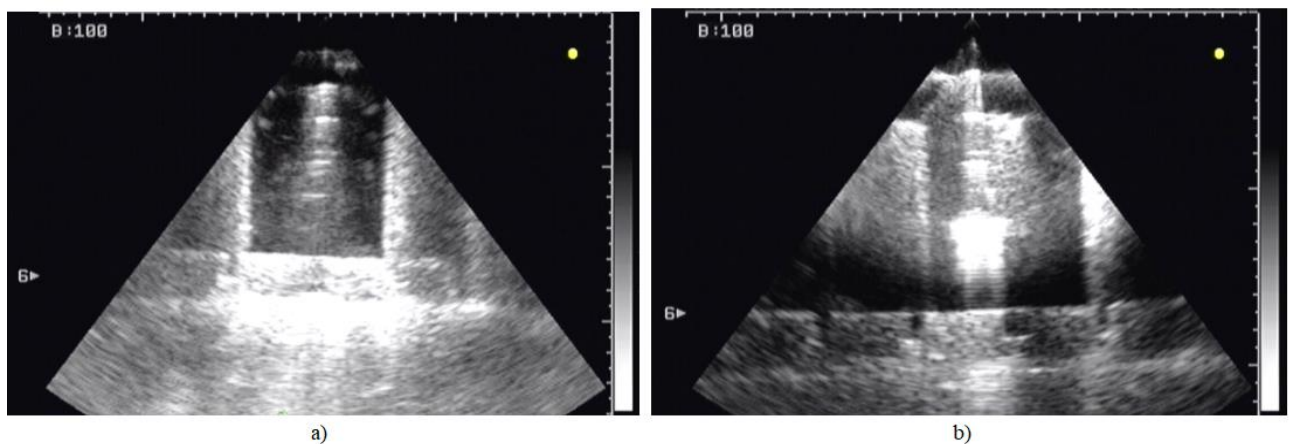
With 2.5 MHz micro – convex transducer acquired ultrasound images of samples irradiated with 0.5 Gy (a) and 2 Gy (b) dose.
